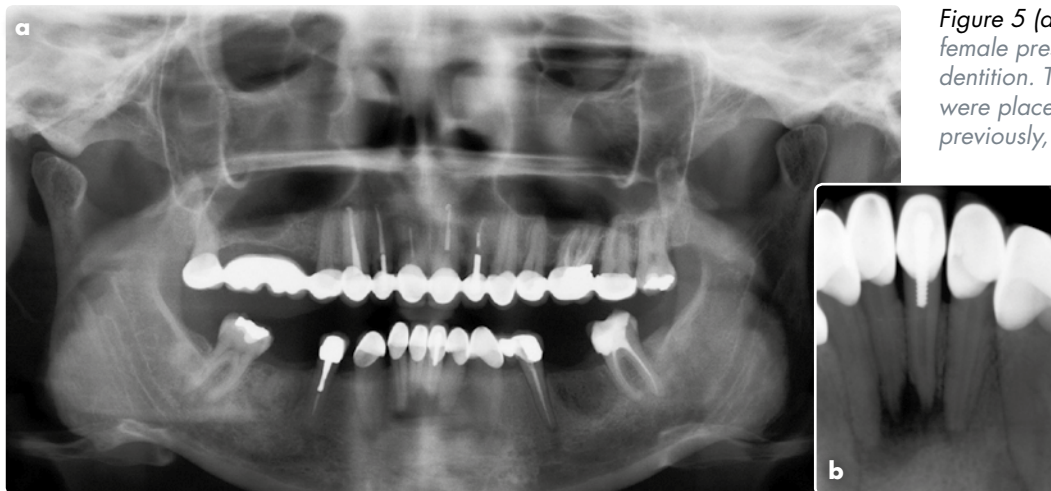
(a) and (b): A 53-year-old female presenting with a failing dentition. The original restorations were placed approximately 15 years previously, but the patient recently had the lower restorations replaced. Her initial complaint was of pain localised to the lower anterior teeth. Fig 5 (b) shows an intra-oral radiograph of the lower anterior teeth. CAD-CAM restorations are not likely to be any less destructive or less problematic in the longer-term
